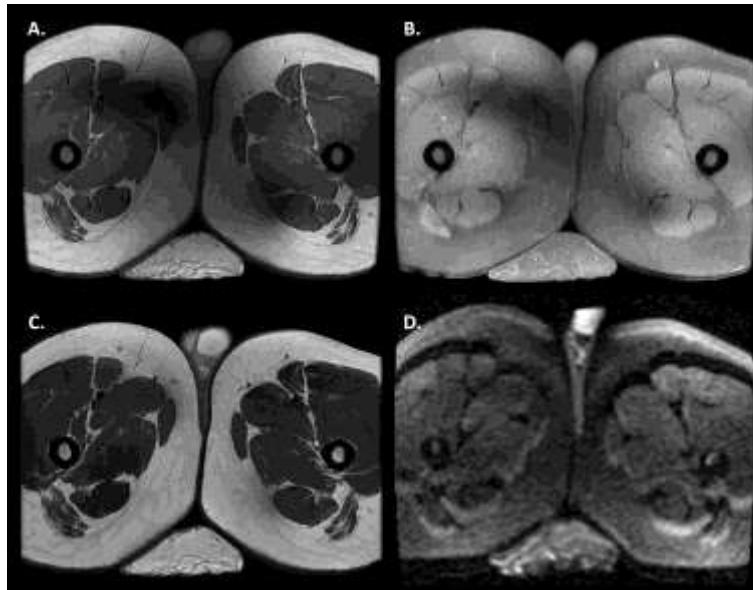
Magnetic resonance images, axial sections, shows a mass with high signal intensity on T1-weighted images (A.); and high signal intensity on T2-weighted images (B.), green arrows. No restricted diffusion noted in the diffusion-weighted imaging (D.)
